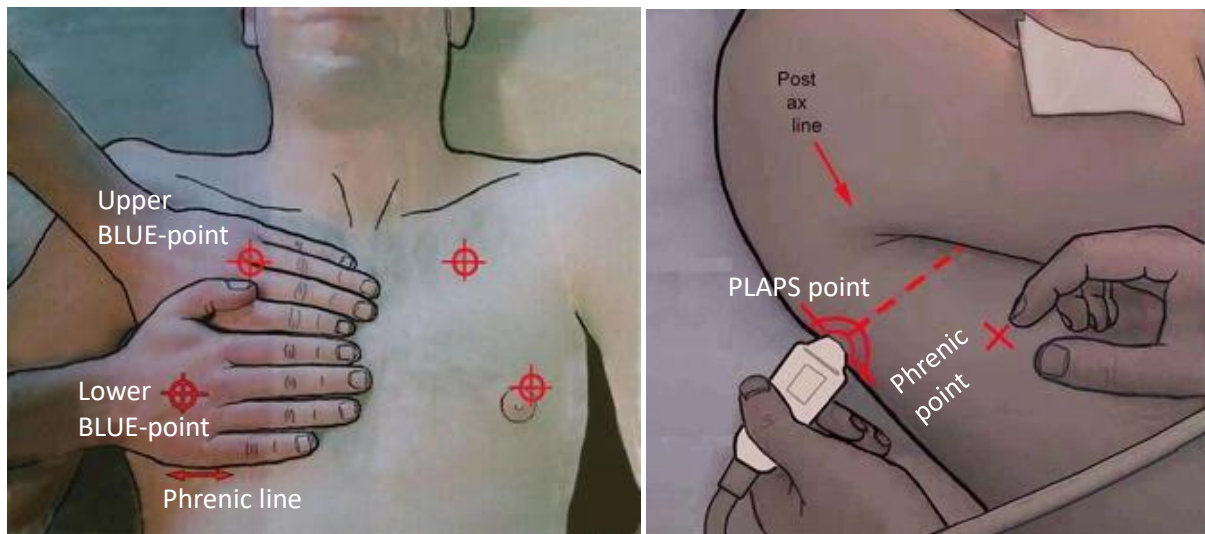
The BLUE-points from the BLUE-protocol. Adapted from Lichtenstein and Mezière 2011. BLUE-hands, or the hand size of the patient, are used for rough measurements of the BLUE-points. Key: BLUE: Bedside Lung Ultrasound in Emergency; PLAPS: posterolateral alveolar and/or pleural syndrome.
